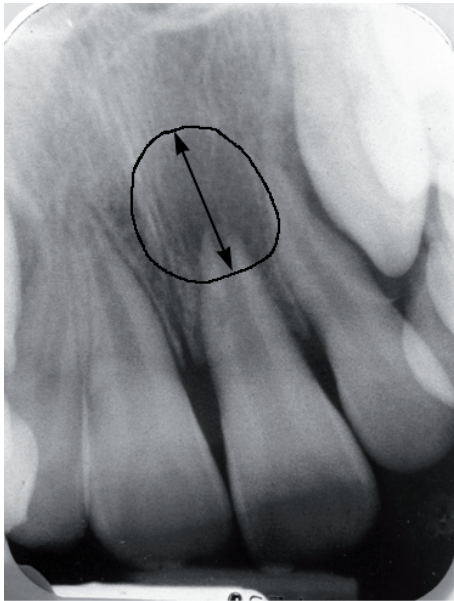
Intraoral periapical radiograph of tooth with incomplete root end closure and associated radiolucency.
